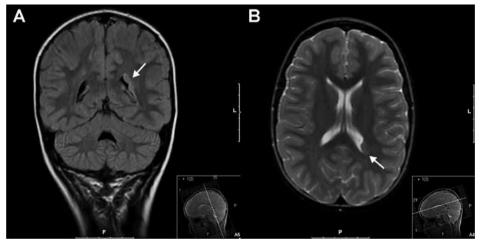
Brain MRI showing unilateral periventricular nodular heterotopia (arrows); (A) coronal FLAIR image and (B) transversal T2-weighted image.
